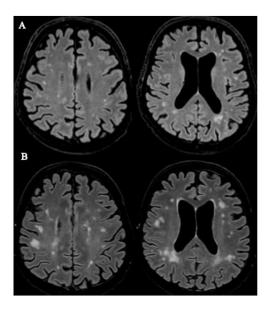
Imaging alterations on MRI two weeks (A), and six weeks (B), after the development of severe ICANS.
